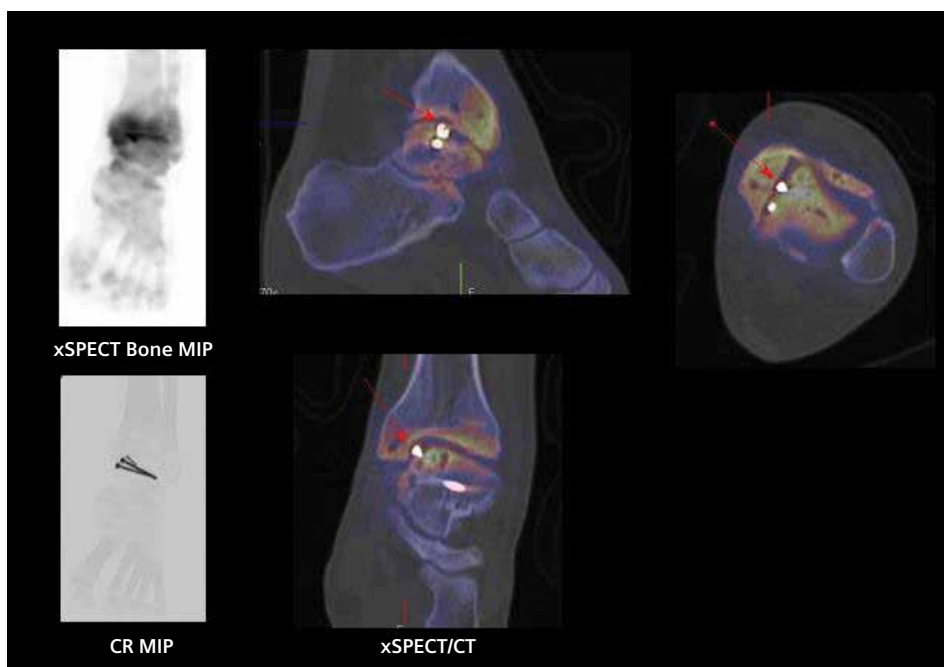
xSPECT Bone maximum intensity projection (MIP) image shows sharp delineation of skeletal hypermetabolism in the talo-tibial joint space, more towards the medial end. The adjacent tibial subchondral bone and medial malleolus also show increased uptake. The CT MIP image shows the lateral orientation of the 3 talar fixation screws, each of which are also delineated in the CT and fused images. xSPECT Bone and CT fused images show skeletal hypermetabolism in the entire articular surface of the lower end of the tibia and the talar articular surface, most prominently in the medial aspect. Metallic hyperdensity within the joint space suggests extrusion of one end of a talar fixation screw into the ankle joint (arrows), which is suggested to lead to impingement between the tibial and talar articular surface with resultant osteochondral erosion, osteoarthritis, subchondral multiple small cyst formation and mild sclerosis. There is slight narrowing of joint space and irregularities in the joint surfaces due to impingement. Increased tracer uptake in the articular surface and subchondral space reflects osteoarthritic changes and reactive stress secondary to impingement.
